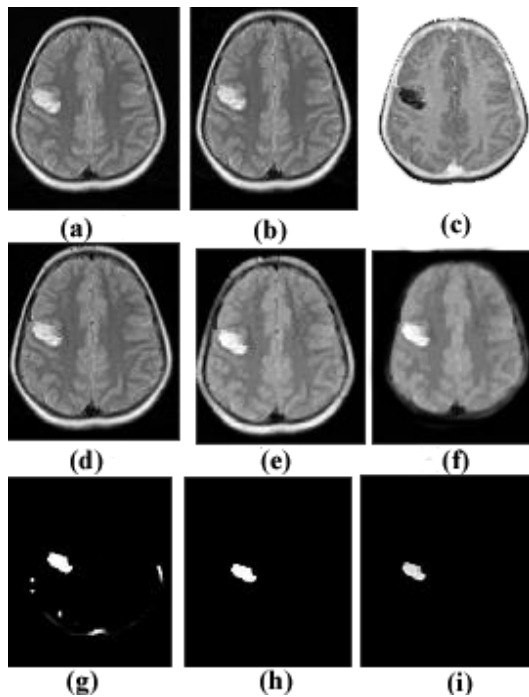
Extraction technique for high grade tumour from T1 weighted MRI slice a) Original image b) Pre-processed image c) Complement and dilated image d) Filtered image e) Image after opening f) Image after closing g) Threshold image h) Morphologically labelled image using connected component labelling i) Segmented gray level image
